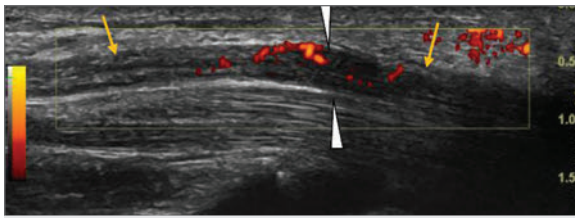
Longitudinal image of the median nerve (yellow arrows) at the level of the carpal tunnel. There appears to be a mild swelling of the nerve as it enters the tunnel (white arrowhead). Doppler imaging demonstrates a mild intraneural vascularity suggestive of carpal tunnel syndrome.
